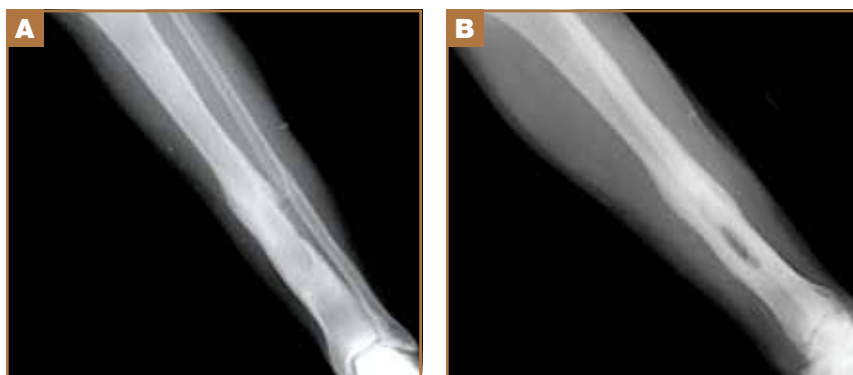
Anterior/posterior radiograph demonstrating fracture callus and union at 18-month follow-up (A). Lateral radiograph demonstrating fracture callus and union at 18-month follow-up (B).
